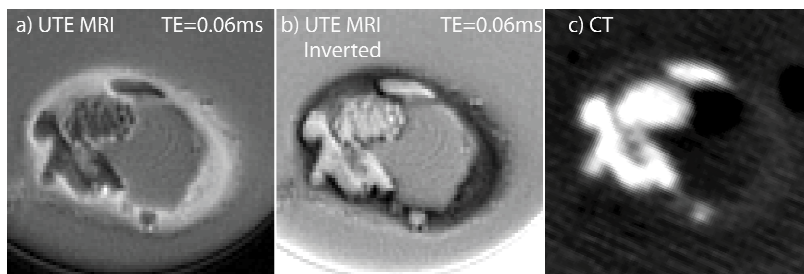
The high-resolution UTE image (a) can be displayed with an inverted colormap (b), yielding an image with remarkable similarity to CT (c) but with better soft-tissue contrast. Note air bubble in CT image.
